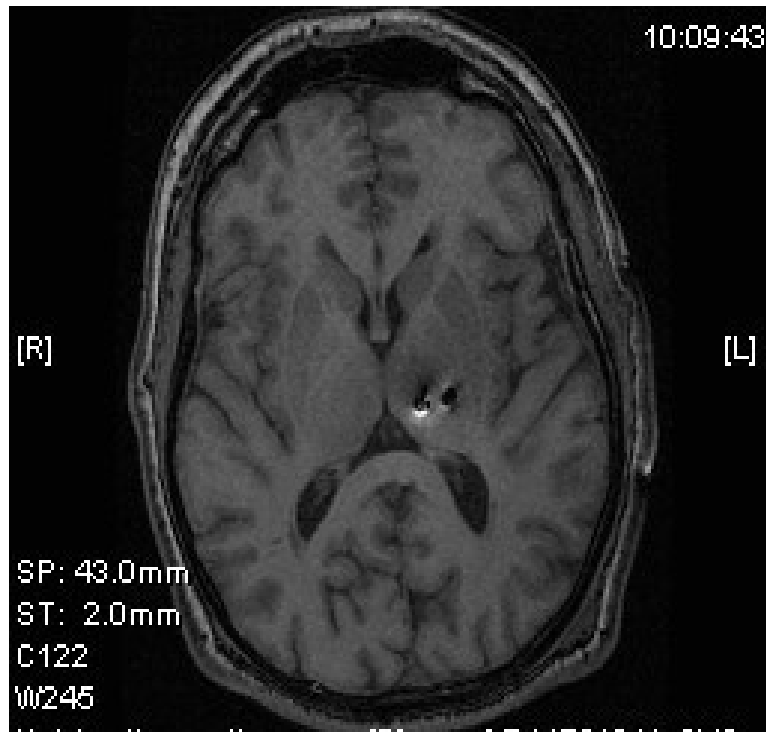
Representative post-operative MRI of a patient with implanted left thalamic DBS leads
